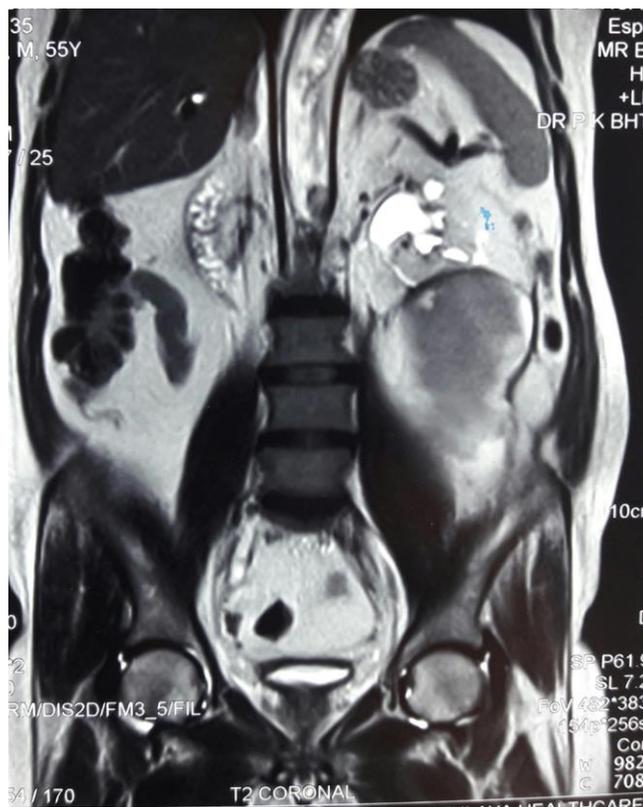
MRI cut showing retroperitoneal hematoma
